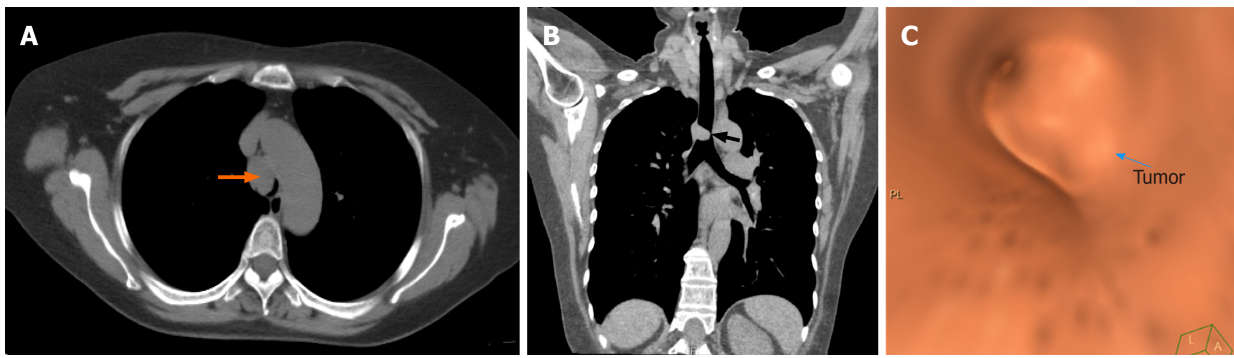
Computed tomographic presentation of the patient. A: Mediastinal computed tomographic scan of the chest showed a 2.4 cm × 2.1 cm homogenous well-defined, dense soft tissue lesion in the left lateral inner wall of the trachea (orange arrows); B: Computed tomographic scan with multiplanar reconstruction showed a round lesion in the lower trachea (black arrow); C: A tumor in the inner trachea observed by computed tomographic virtual bronchoscopy (blue arrow).
